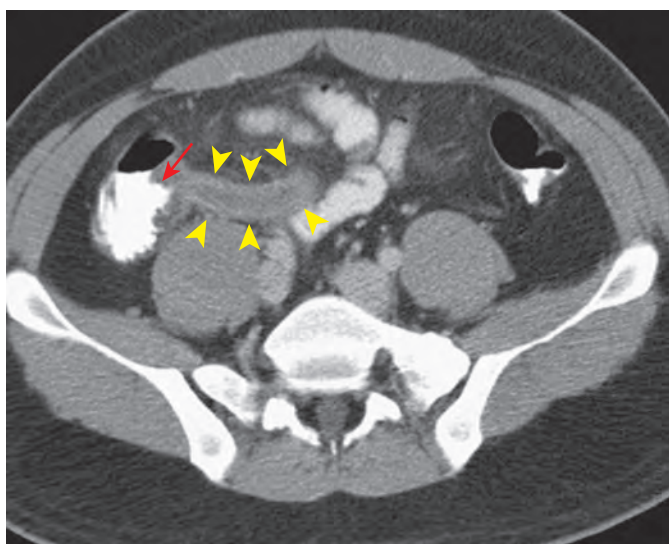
Acute appendicitis on enhanced CT. The appendix (arrowheads) is distended, with enhancement of the thickened appendiceal wall and periappendiceal soft tissue stranding. Note the funneling of enteric contrast in the thickened cecum toward the appendiceal orifice, the so-called arrowhead sign (arrow).
